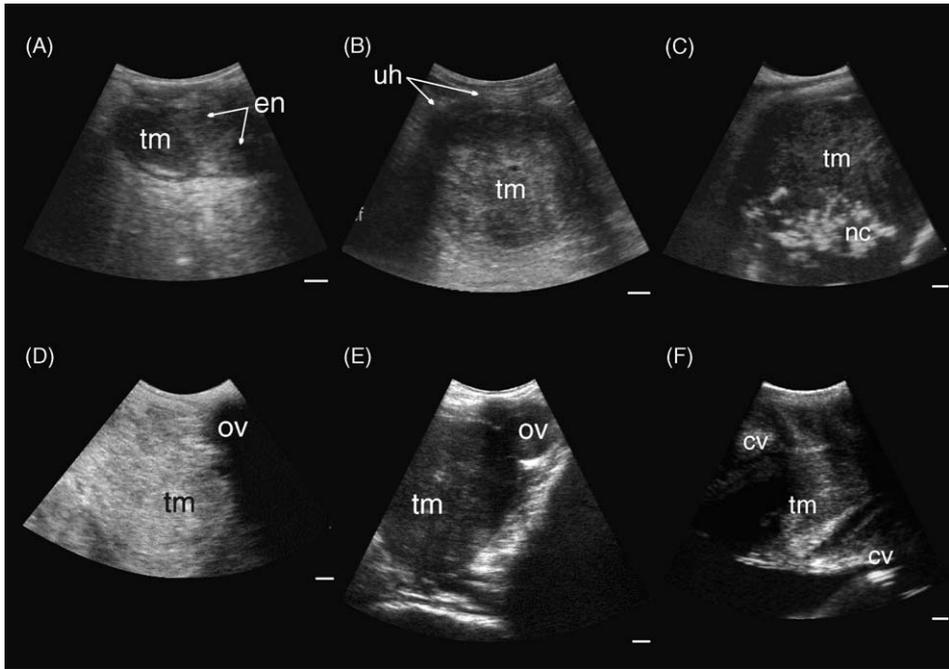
Ultrasonographic images of uterine (A–C), ovarian (D and E) and cervical (F) tumours (tm) in white rhinoceroses: (A) A 4 cm × 2 cm mural tumour in left uterine horn. The tumour is lower echogenicity compared with the endometrium (en) in a nulliparous female, no. 374. (B) A 7 cm mural tumour compressing the uterine horn (uh) in a nulliparous female, no. 471. (C) A 12.5 cm tumour with central areas of necrosis (nc), no. 476. (D) A 5 cm para-ovarian tumour in cycling, multiparous, 30-year-old female, no. 174. (E) A 12 cm para-ovarian tumour a non-cycling, uniparous, 32-year-old, no. 696. (F) Longitudinal view: the low echogenic base of a polyp (arrows) in the cervix in a nulliparous female, no. 476. The tumour is located between the cervical folds (cv) with its growths directed towards the vagina. Scale bars represent 1 cm.
